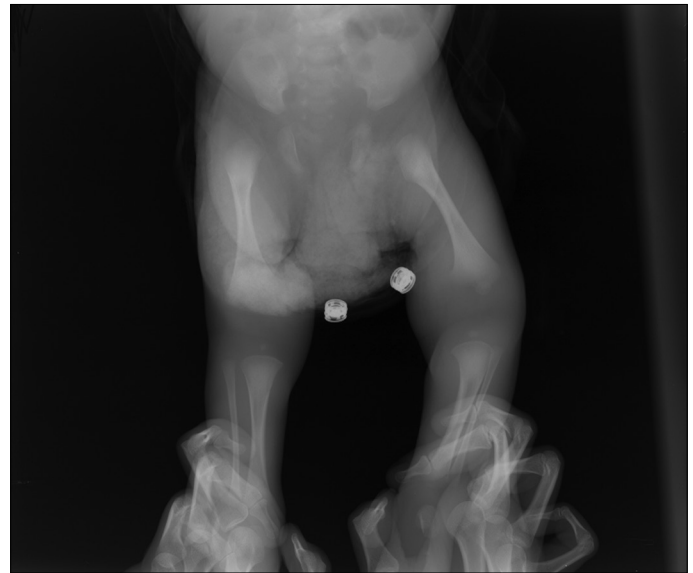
Direct radiography imaging which generates the appearance of swelling in the surrounding soft tissues
